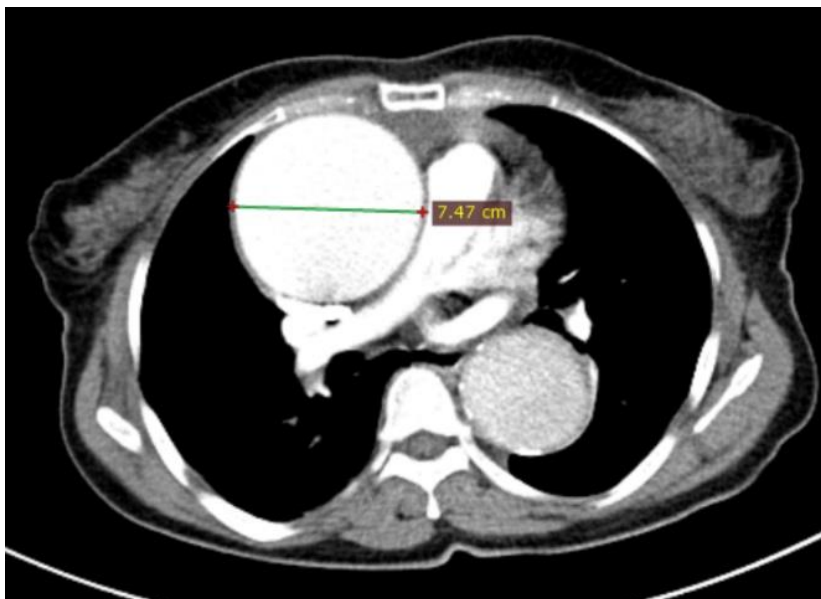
Computed Tomography of the ascending aorta showing a large aneurysm in a HIV patient.
